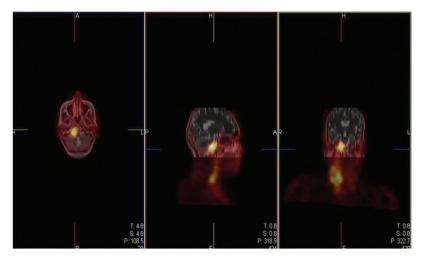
Fused SPECT/MRI images confirmed the abnormal lesion in the right side of the skull base in the junction of the medulla and spinal cord
